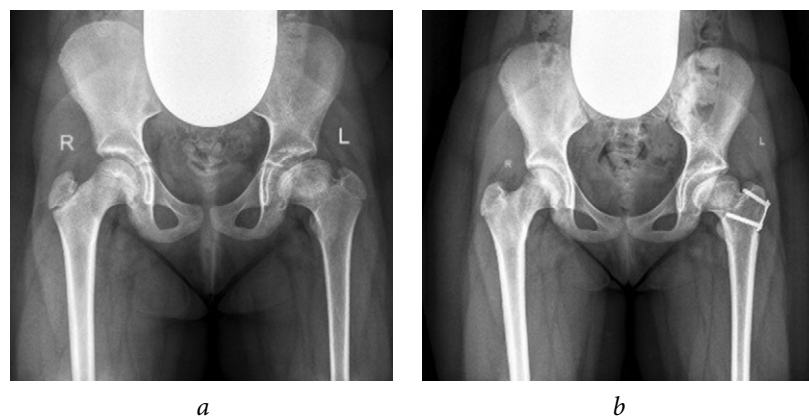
Radiographs of patient K (9 years old) diagnosed with Perthes disease on the left side but was in the recovery stage: *a*, before surgery; *b*, 2.5 years after the trochanteric epiphysiodesis on the left
